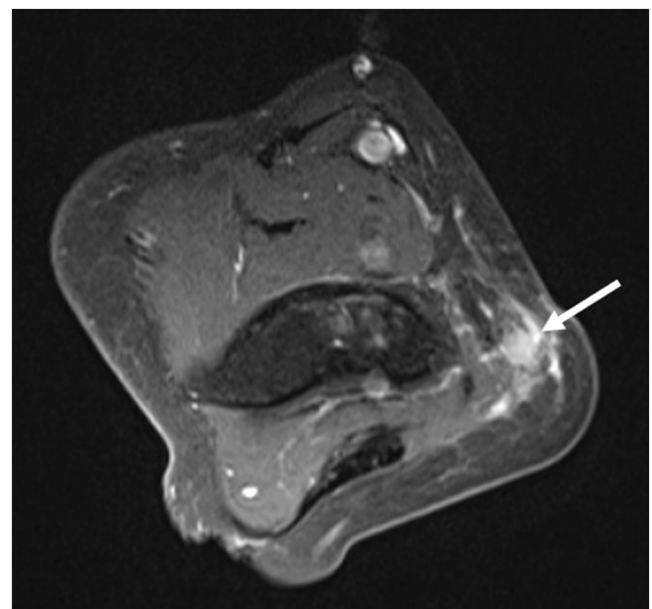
Contrast-enhanced T1-weighted axial image demonstrated an enhanced lesion (arrow).
